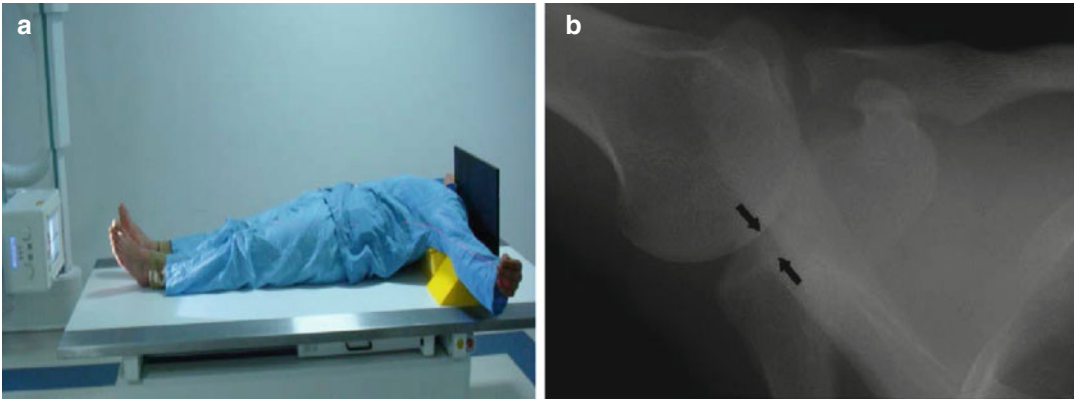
(a) Position of the patient and x-ray device during the axillary radiography. (b) Image of axillary radiography. Arrows show congruence of glenohumeral joint
